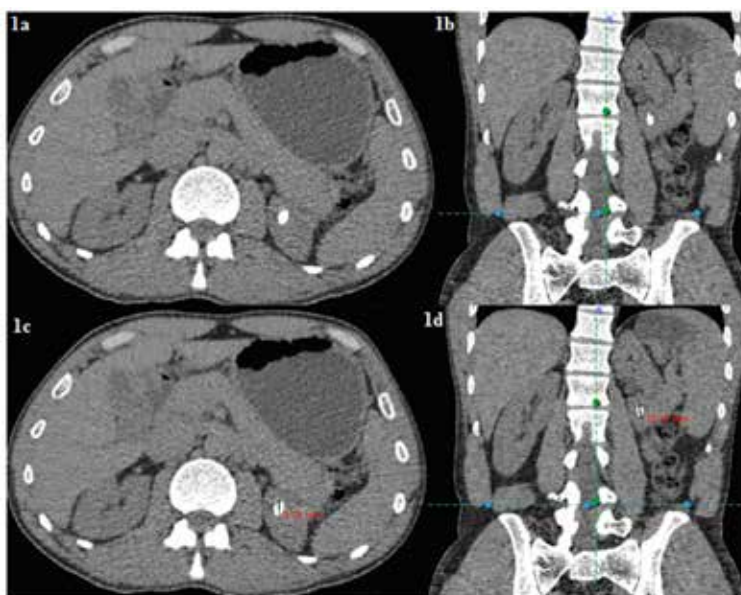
a-d. CT view of preop renal lower pole anteromedial calyceal stone (~12,2x9,4x7,4mm)
